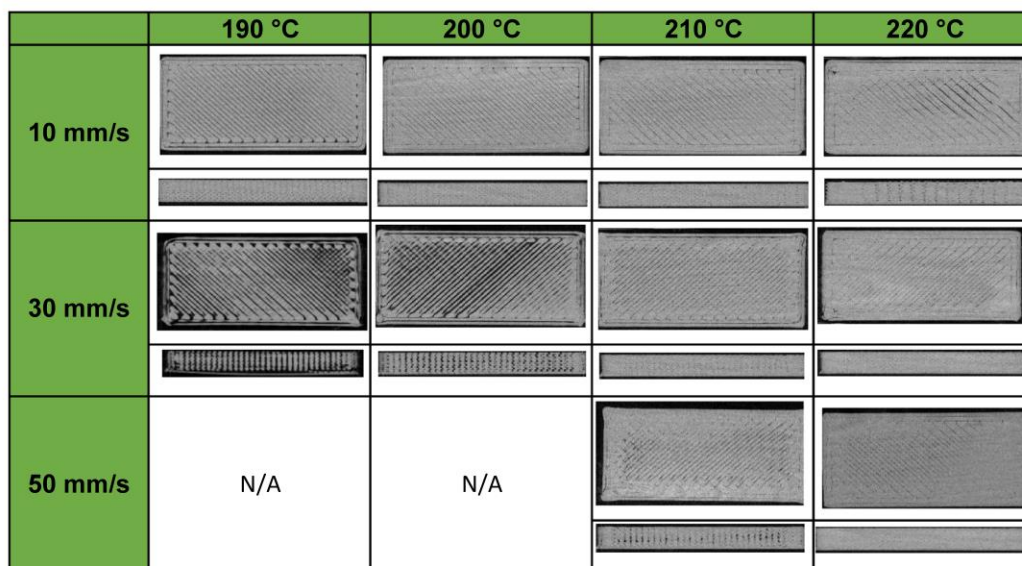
X-ray microtomography slices of cuboids (top and side) from PVA-K20 at varying printing speeds and nozzle temperatures.
